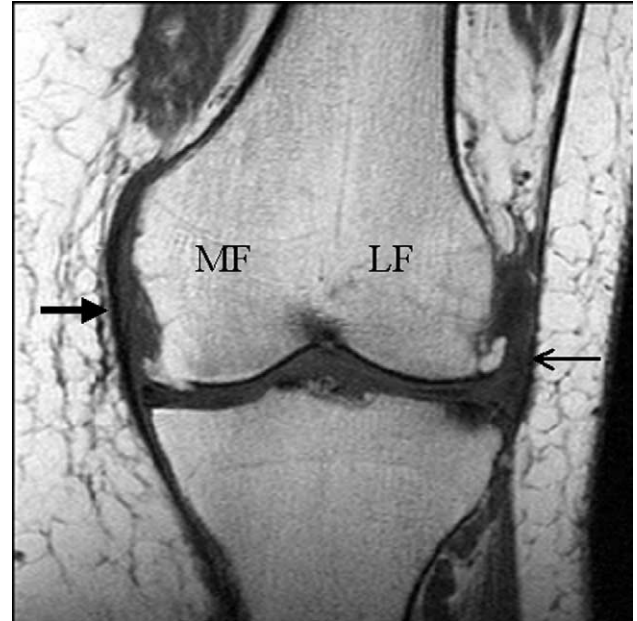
Coronal T1-weighted spin echo. This image shows grade 3 osteophytes of MFc and LFc, and a grade 2 osteophyte of LTc with adjacent subarticular marrow abnormality. Additionally, the lateral meniscus shows a bucket-handle tear (grade 3) of the body region. The MCL (large arrow) and iliotibial band (small arrow), which is a portion of the LCL, are intact. Articular cartilage is not delineated with T1-weighted spin-echo images.
